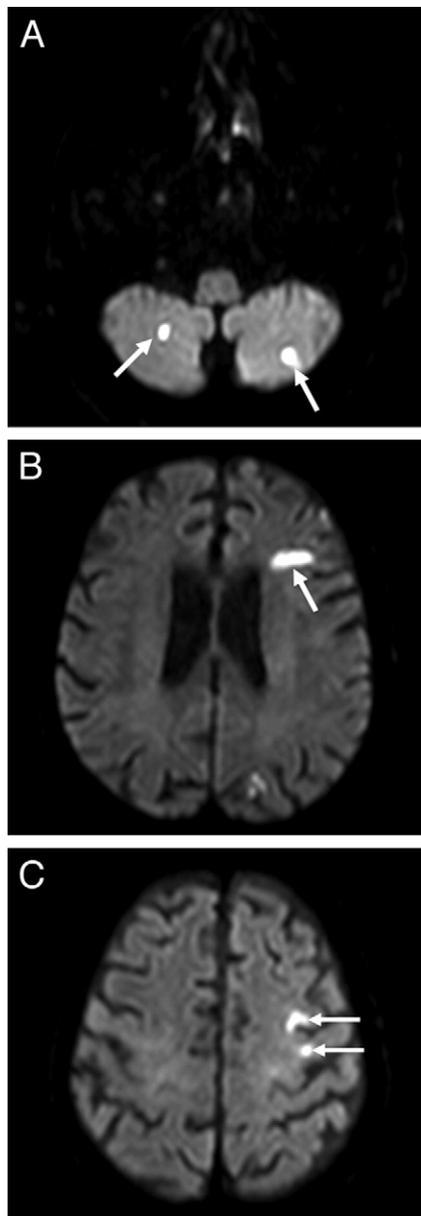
DW-MRI Images Following TA-TAVI
